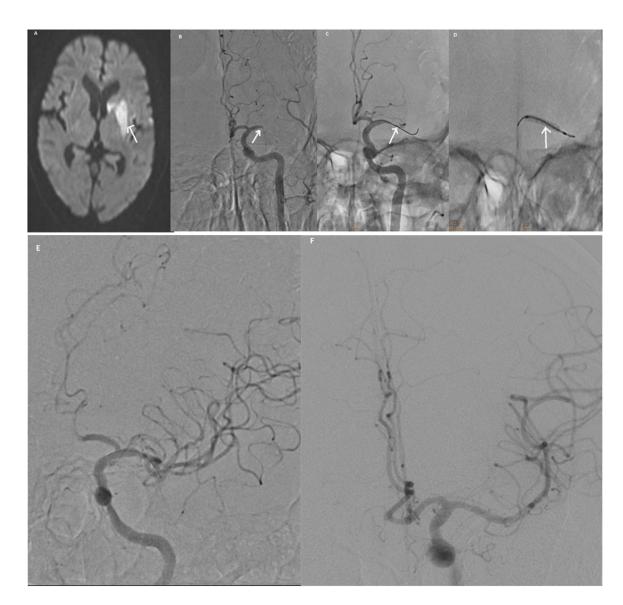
(A) Sixty-three-year-old male with acute stroke and MRI showing restricted diffusion (a) in left capsuloganglionic region. DSA done after IV thrombolysis showed total occlusion of left M1 (arrow in B) and lesion accessed with 1.5-mm maverick balloon (C) and subsequent angioplasty done with 2.5-mm maverick system (D). (B) Post-procedural angiogram showing good recanalization (E). Delayed angiogram showed good intracranial circulation (F).
